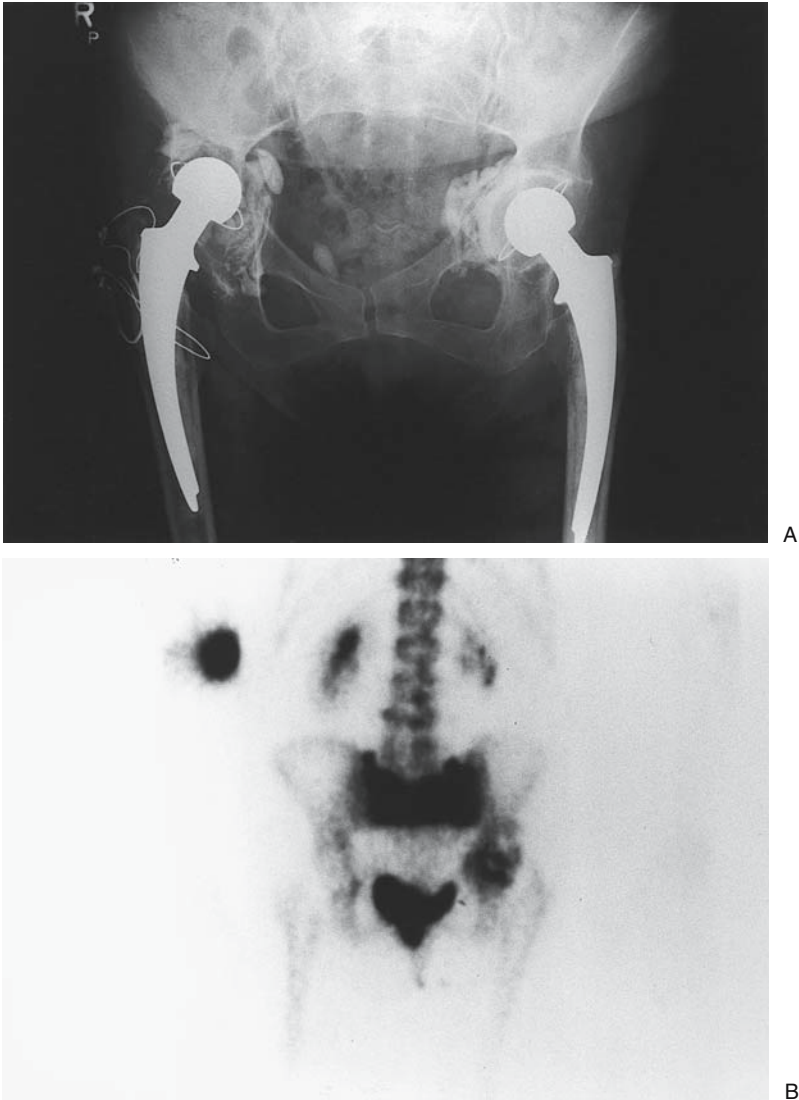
This 84-year-old woman presented with severe hip pain after a car ride. The patient had bilateral hip replacement approximately 15 years before presentation. (A) AP pelvic radiograph demonstrates a patient with significant diffuse osteopenia and two hip replacements. Both hips appear to have some loosening of the acetabular components but demonstrate no acute changes. (B) Delayed image from a Tc 99-MDP bone scan demonstrates significant uptake in the left acetabulum. However, there is diffuse marked increase uptake throughout the sacrum. This pattern of uptake is consistent with a sacral insufficiency fracture.
